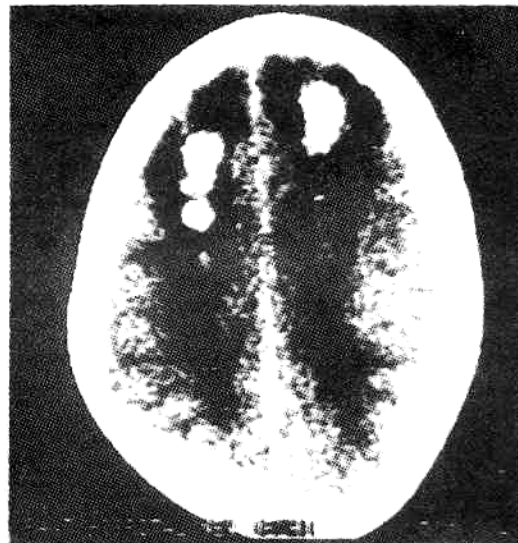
Intracranial deposits of granulocytic sarcoma as seen in CT Scan in a 12 year old boy.
